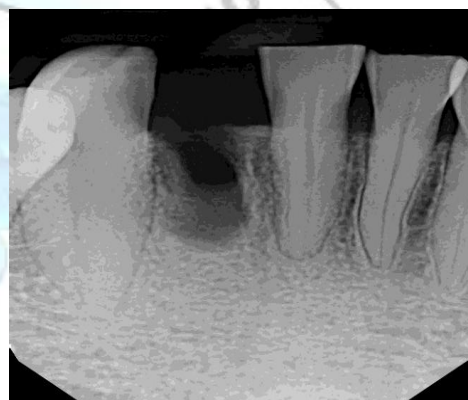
Post extraction Periapical radiograph
